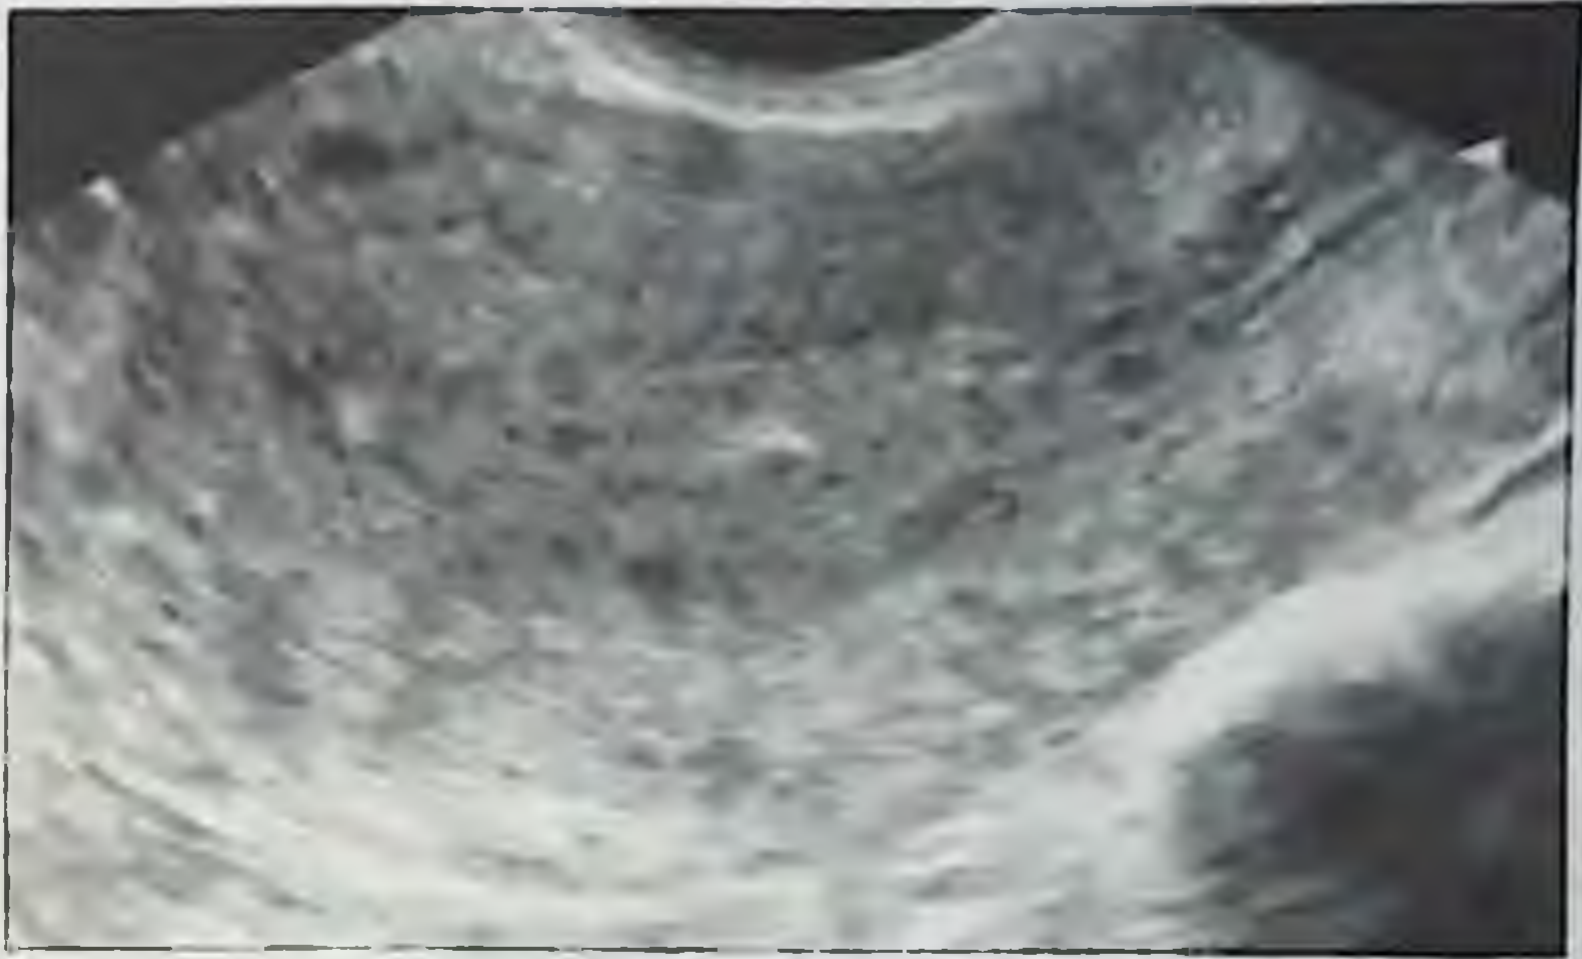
Ultrasound picture of glandular cystic endometrial hyperplasia*
